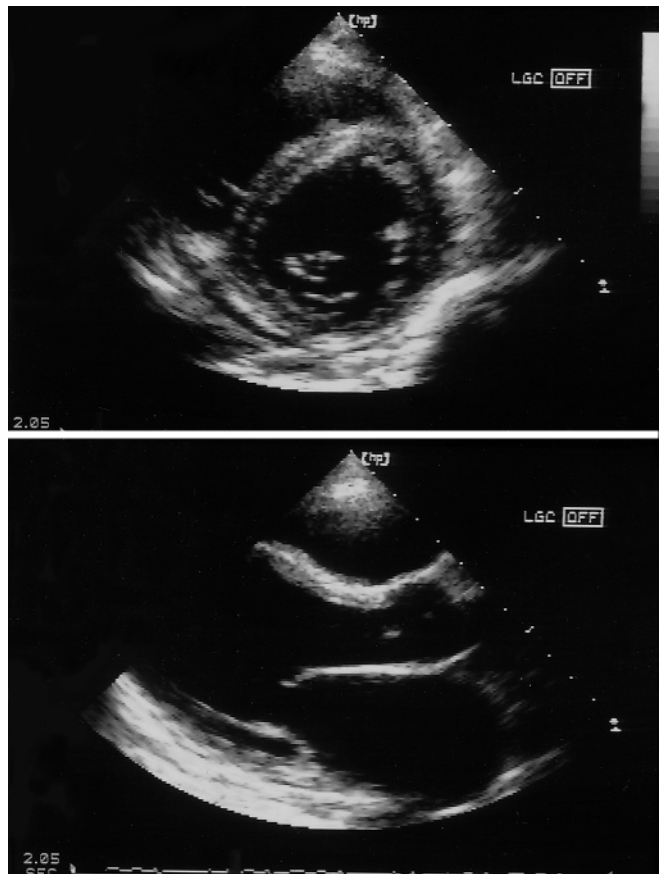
Echocardiography indicated severe hypokinesis of the cardiac wall with a left ventricular ejection fraction of 32%. The left cardiac wall is very thin
